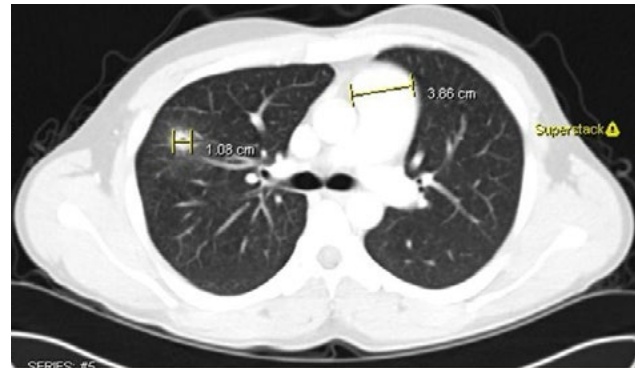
Computed tomography of the chest reveals a 1.08-cm cavitory nodule that responded to voriconazole treatment.
